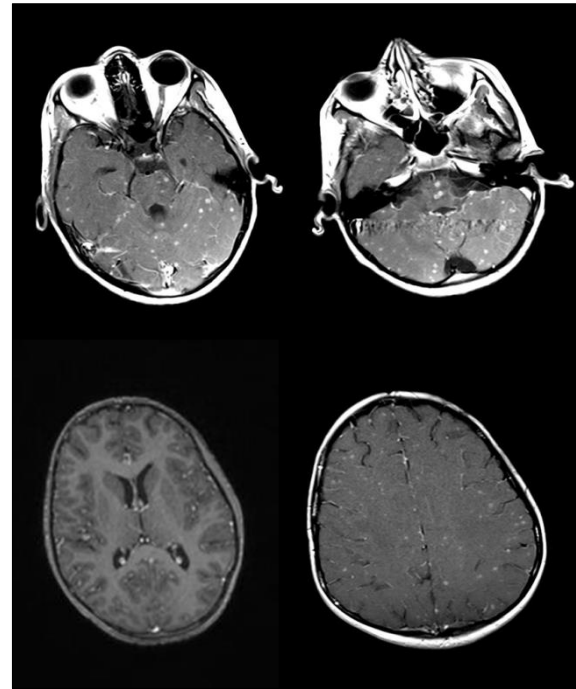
MRI brain (axial view) showing starry sky appearance pattern.
